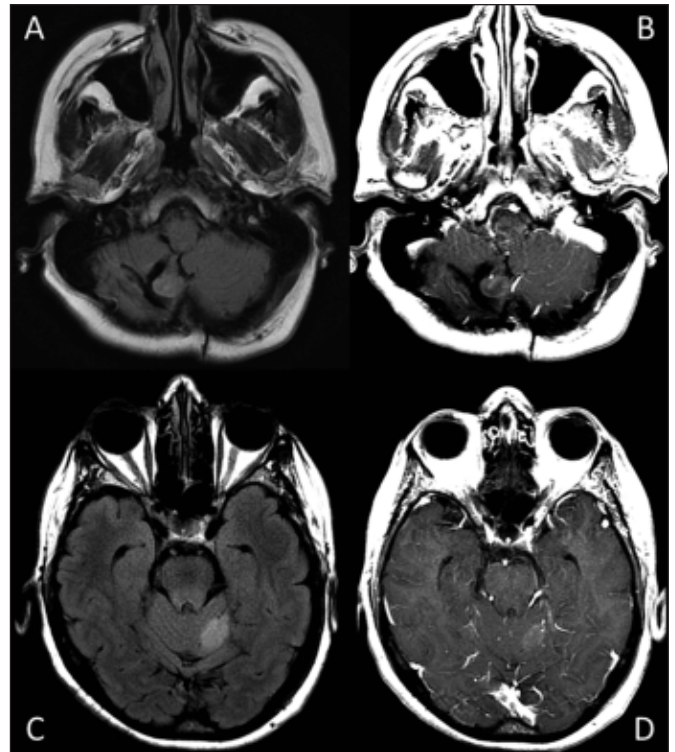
(A) Axial FLAIR image demonstrates recurrent FLAIR hyperintense tumour nodule in the resection bed. (B) Axial T1-weighted image with gadolinium contrast demonstrates enhancement of the nodule. (C) Axial FLAIR image demonstrates a new hyperintense left superior cerebellar mass. (D) Axial T1-weighted image with gadolinium contrast demonstrates enhancement of the new left superior cerebellar mass.
